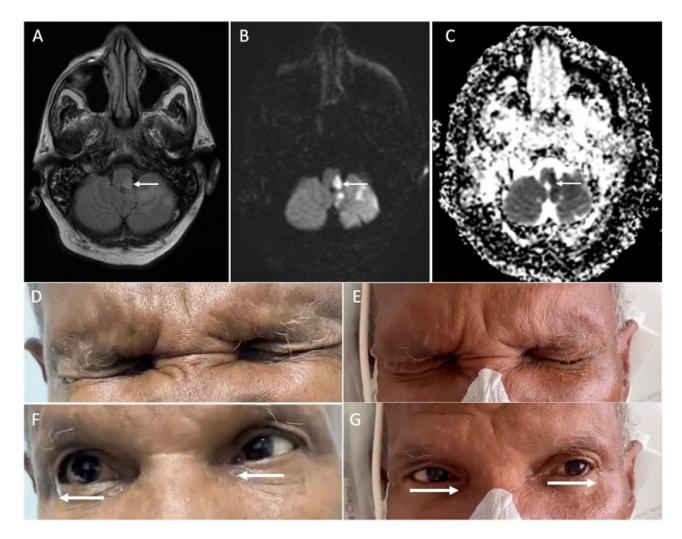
(A) Flair hyperintense focus at the left side of the medulla. (B) DWI sequences confirmed the ischemic event, (C) showing diffusion restriction. Classic features of ischemic infarct in left medulla. (D, F) Ocular contrapulsion followed by (E, G) ipsipulsion after 7 days.
